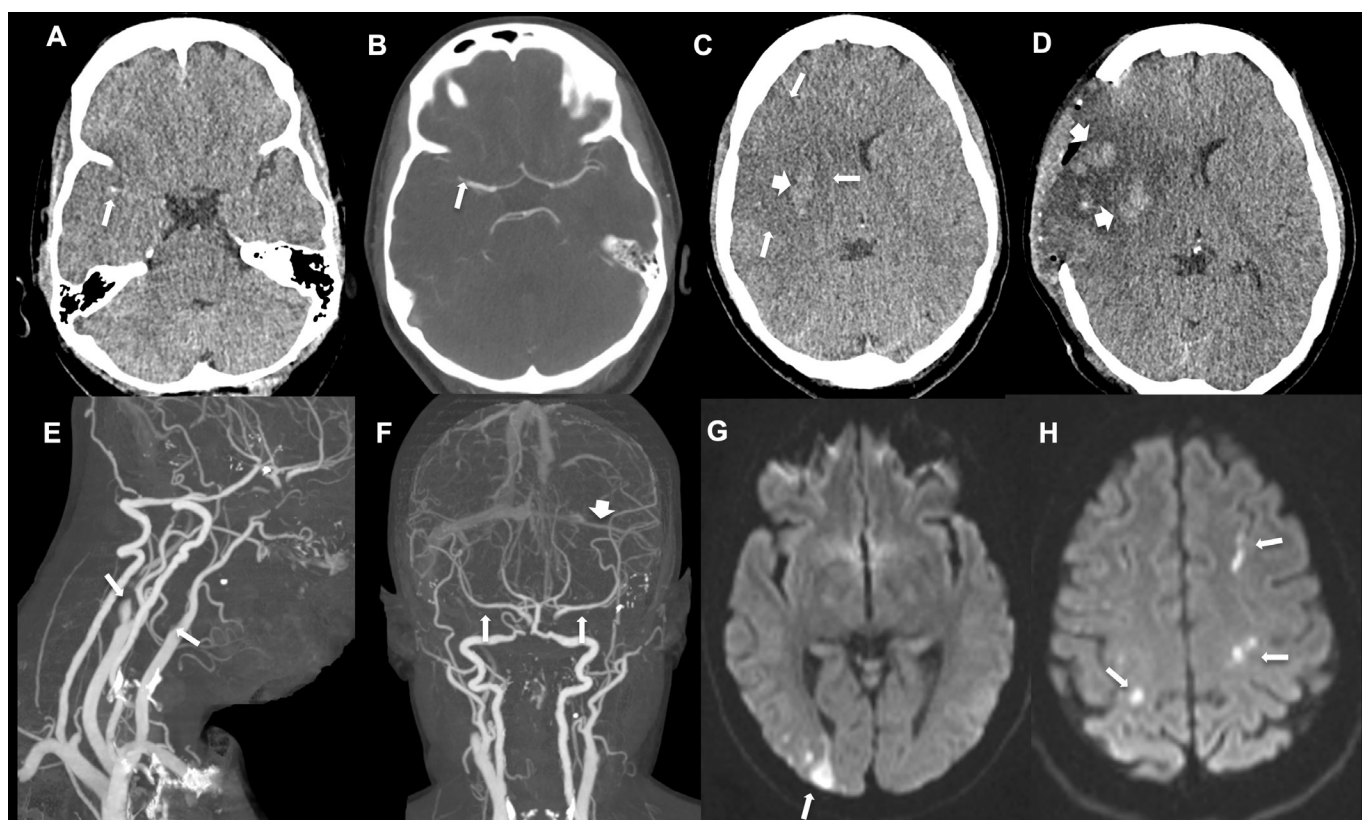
Patient 1: (A–D) non-enhanced CT (A) shows hyperdense clot in the distal right M1 segment (arrow), which corresponds to site of the occlusion demonstrated on the CT angiogram (B, arrow). The non-enhanced CT at the level of the basal ganglia (C) shows a large acute right middle cerebral artery infarct with loss of grey–white matter differentiation (arrows) and early haemorrhagic transformation (short arrow). A non-enhanced CT following emergency craniectomy (D) demonstrates swelling of the right hemisphere and extension of the haemorrhagic transformation (short arrows). Patient 2: (E–H) the extracranial CT angiogram (E) shows occlusion of both internal carotid arteries (arrows), the right being occluded from its postbulbous portion and the left at its origin. The intracranial CT angiography (F) demonstrates patent middle cerebral arteries bilaterally (arrows), which fill via collaterals predominantly from the posterior communicating arteries. There is also a lack of filling of the mid-portions and distal portions of the left transverse sinus (short arrow), suspicious of a thrombosis, later confirmed with a dedicated CT venogram. Magnetic resonance diffusion-weighted images (G,H) reveal several acute infarcts in the right occipital lobe (arrow in G) and centrum semiovale bilaterally (arrows in H), corresponding to cortical as well as deep and superficial arterial borderzone territories.
